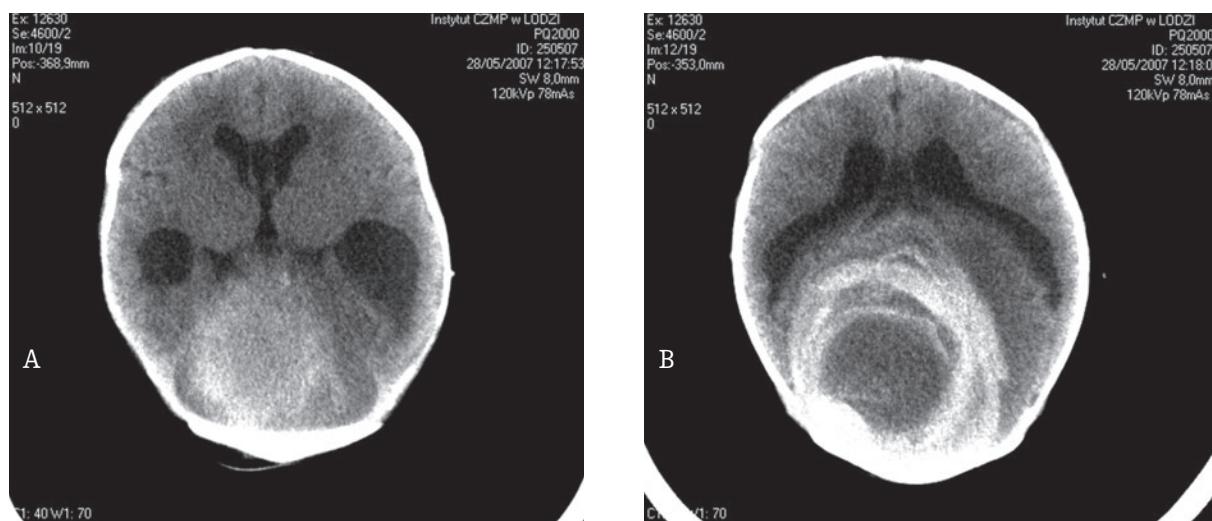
Axial noncontrast CT scan (A) and scan after i.v. contrast injection (B) shows hemorrhage in the tumor (teratoma) involving the occipital and parietal lobes of the brain. Postcontrast scan reveals enhancement of the tumor capsule (B).
